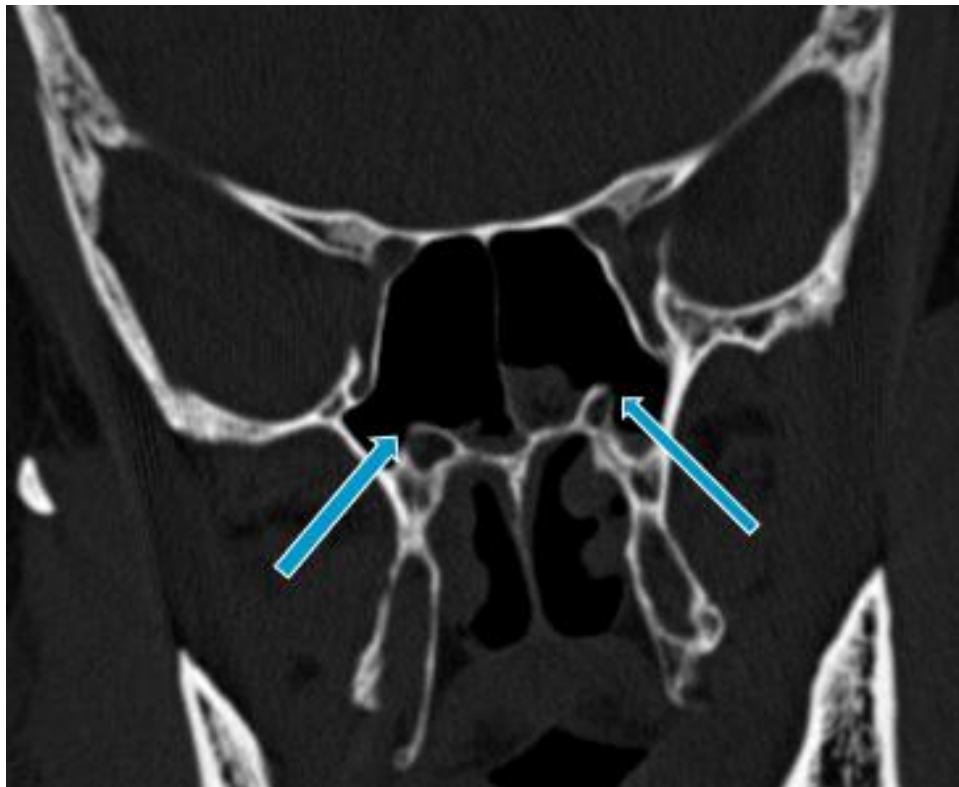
CT coronal section of sphenoid sinus showing protrusion and dehiscence of vidian nerve (arrows)
